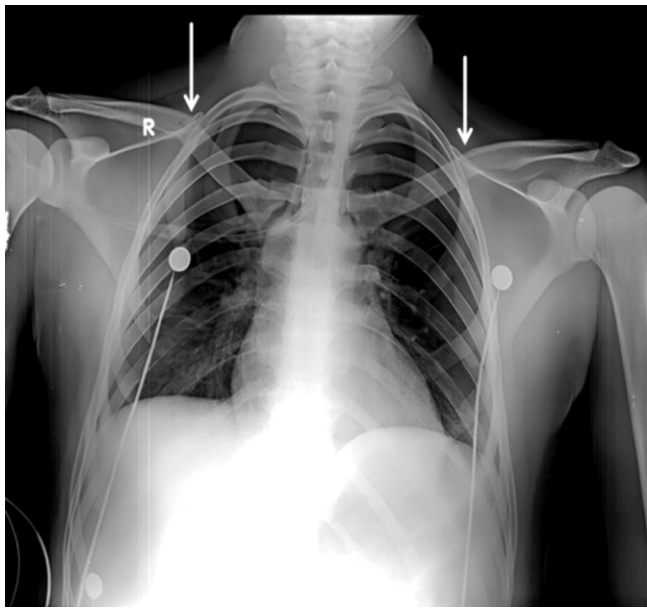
Initial anteroposterior radiograph of both clavicles showing no obvious fracture lines. Findings were inconclusive.
